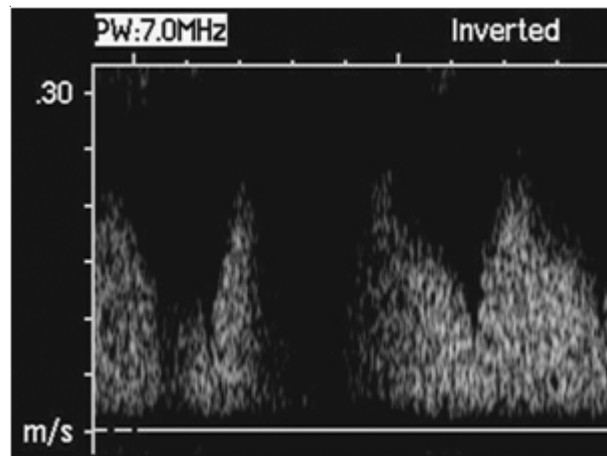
Doppler mode US showing low-resistant waveforms of the pulmonary nodule by a systemic arterial supply.
